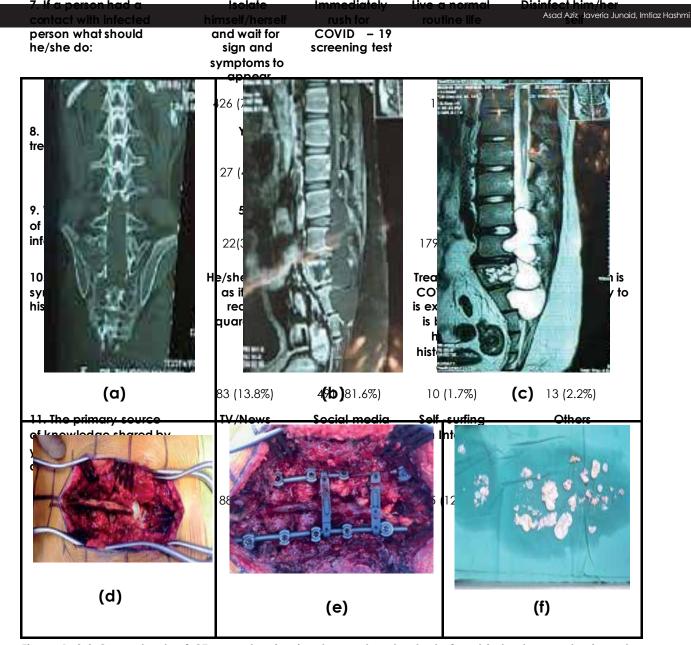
(a) Coronal cuts of CT scan showing involvement and extant of cyst in lumbosacral spine, also involving the right side sacrum (b) Sagittal cut of MRI T-1 image – showing dark signals around the involved area, as CSF and fluid appears dark. Sagittal cut of MRI (c) T-2 image – showing high uptake along posterior border of L3-S1 also involving vertebral body of S1 (d, e) Peroperative images of cyst andfusion sugery (f) Postoperative removed cyst.
